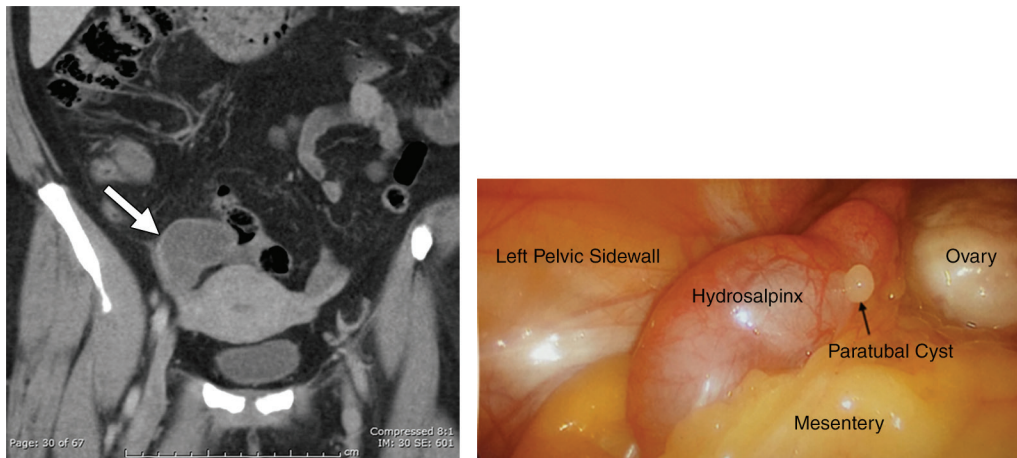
Late PID: hydrosalpinx in two different patients. (a) Coronal contrast-enhanced CT image of a 50-year-old woman presenting with right lower quadrant pain shows a dilated fluid-filled right fallopian tube with a thin nonenhancing wall (arrow) and incomplete septa. (b) Intraoperative photograph of a 32-year-old woman shows a dilated fallopian tube and its relationship to the adjacent ovary, uterus, pelvic sidewall, and mesentery. Note the incidental finding of a small paratubal cyst.
